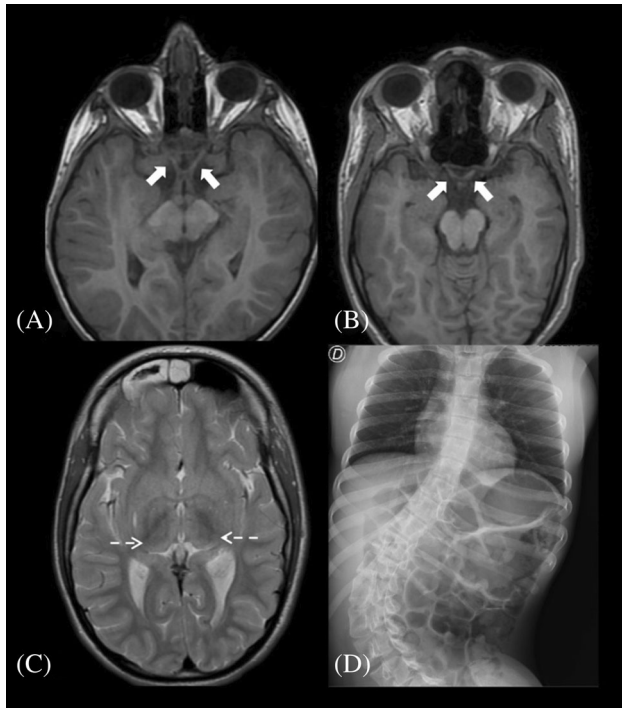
Brain MRI and thoracoabdominal X-rays in PTCO3 patients. T1W axial brain MRI showing atrophy of both optic nerves (white arrows) in patient 1 (A) and patient 2.1 (B). (C) T2W axial brain MRI. Hyperintensity and volume loss of the thalami (white arrows) in patient 2.1. (D) Thoracoabdominal X-ray demonstrating severe lumbar scoliosis in patient 2.1.
